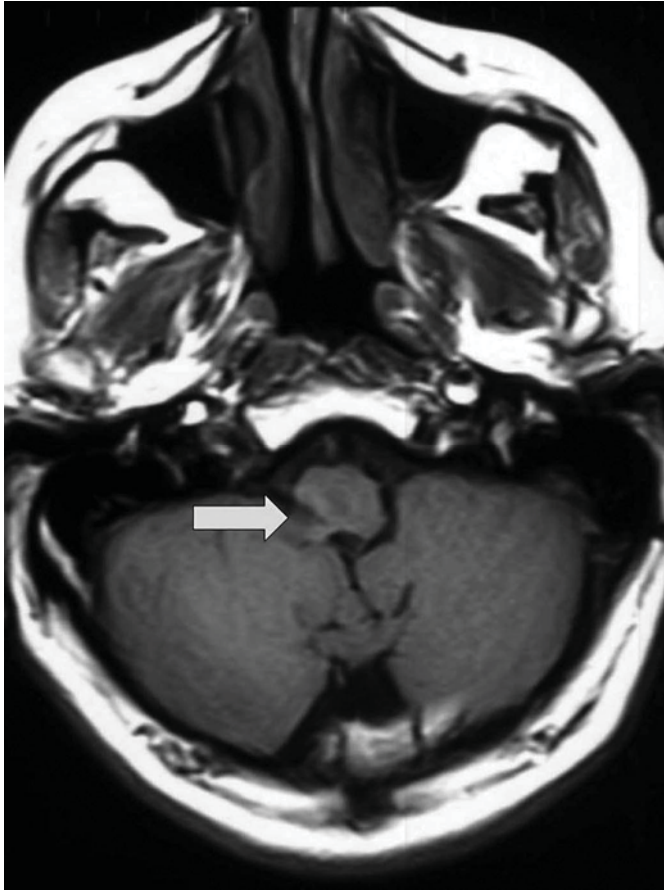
MRI T2 sequence showing a hyperintense lesion (arrow) in the right lateral medullary region.
